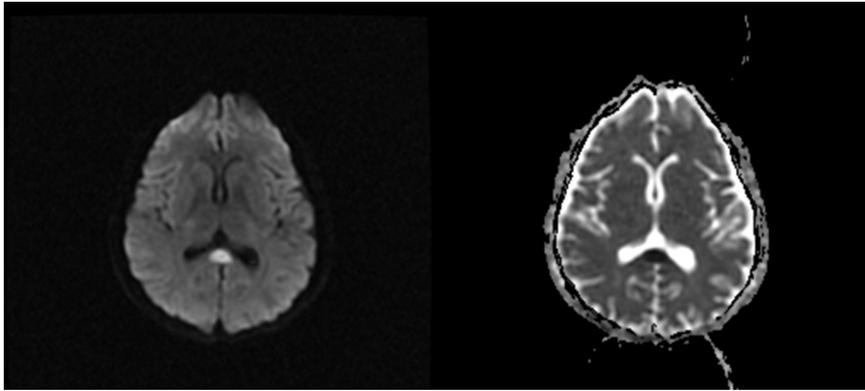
Upon Presentation: Axial Diffusion-weighted imaging (DWI, B100 tensor on the left and ADC map on the right) demonstrates high signal within the splenium of the corpus callosum with loss of signal on ADC.
